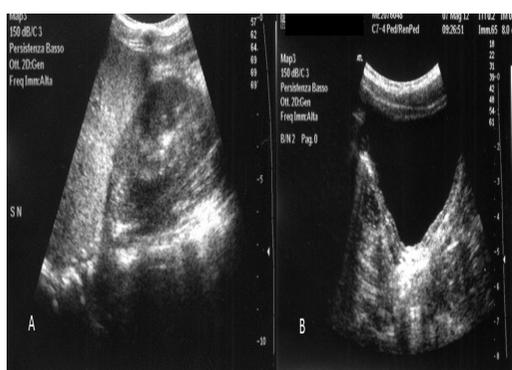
(A) Ultrasound showing left kidney; (B) Ultrasound picture of the bladder.
